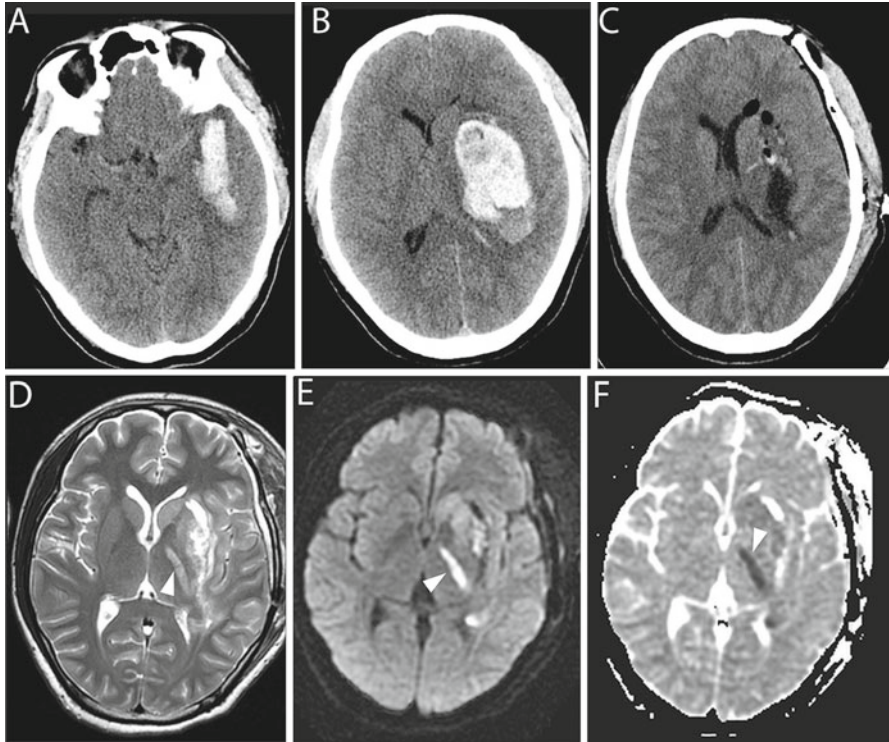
Intracerebral hemorrhage requiring surgical evacuation. This 37-year-old male presented with acute onset headache, nausea and vomiting, aphasia, and progressive right hemiparesis. (a, b) CT revealed a left putamenal hemorrhage with heterogeneous densities of blood. The hematoma was found to come within 1 cm of the cortical surface (a) and was deemed a surgical lesion. (c) Emergent craniotomy was performed and the entire hematoma was removed. (d–f) The patient had no clinical improvement following surgery. Delayed MRI revealed persistent edema in tissue adjacent to the hematoma cavity with hyperintensity in the posterior limb of the internal capsule (arrow). Diffusion-weighted imaging (e) and apparent diffusion coefficient map (f) confirmed the stroke (arrow (e) and (f))
